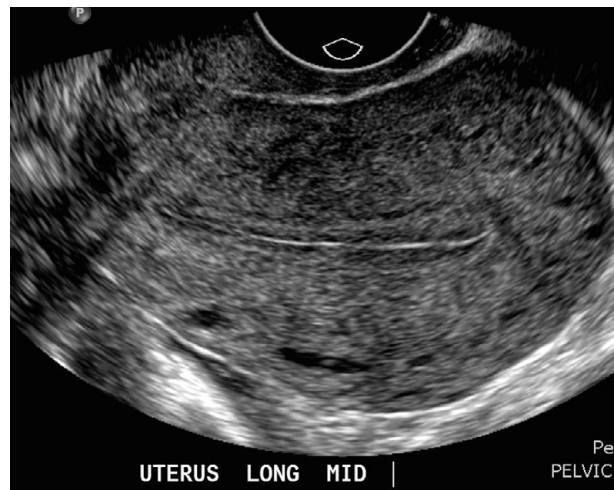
Ultrasound image showing the endometrial stripe (visible as a thin echogenic line) at centre of uterus. [Case courtesy of Dr Alexandra Stanislavsky, Radiopaedia.org, rID: 30417](#)
